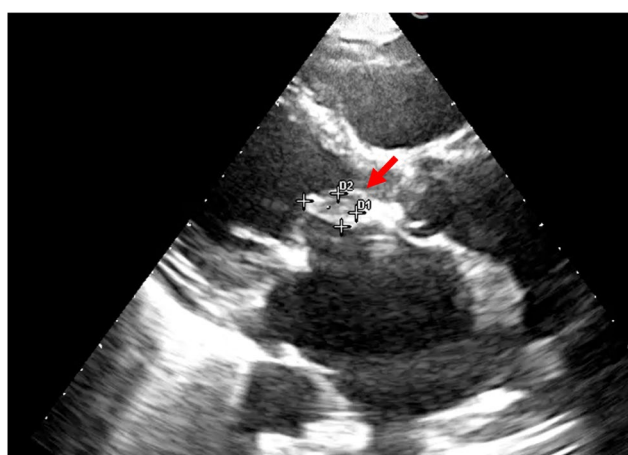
Transthoracic image of a large vegetation (red arrows) on the anterior leaflet of the mitral prosthesis. D1 and D2 indicates the linear diameters, which were 12 and 8 mm, respectively. Parasternal, long axis view. case 5
